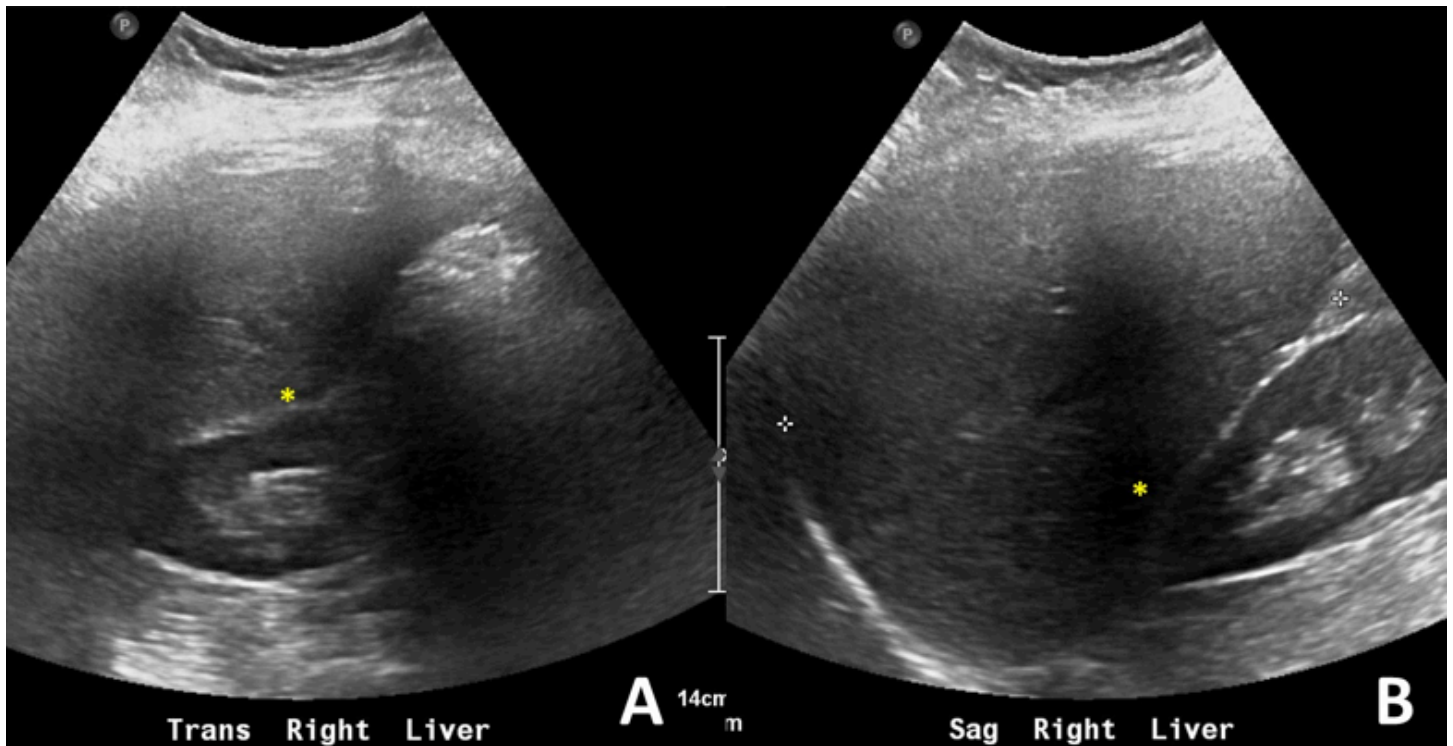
Ultrasound images from our patient with gallbladder agenesis. Stars (*) are located at the interface between the liver and right kidney, and the lack of a fluid-filled sac in the subhepatic space represents the absence of a gallbladder. (A) Sagittal view of the liver. (B) Transverse view of the liver.
